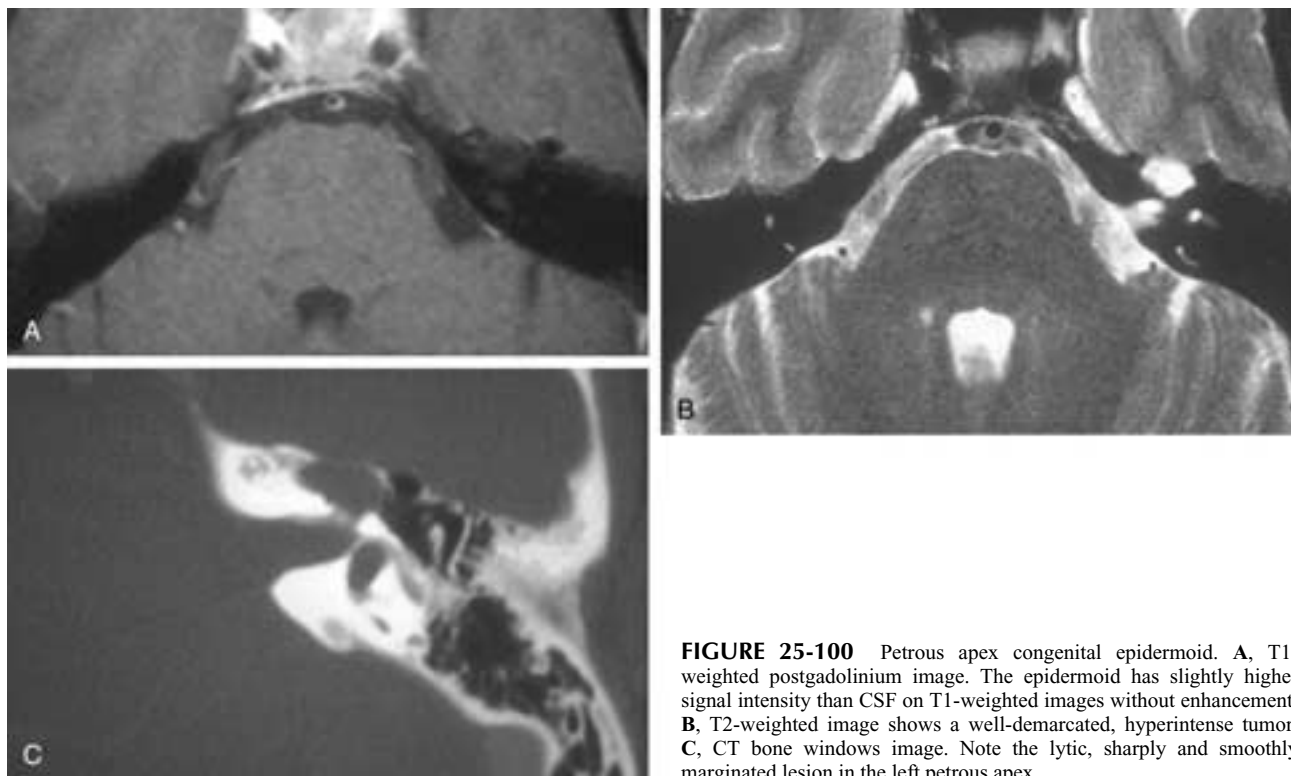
Petrous apex congenital epidermoid. A, T1-weighted postgadolinium image. The epidermoid has slightly higher signal intensity than CSF on T1-weighted images without enhancement. B, T2-weighted image shows a well-demarcated, hyperintense tumor. C, CT bone windows image. Note the lytic, sharply and smoothly margined lesion in the left petrous apex.
